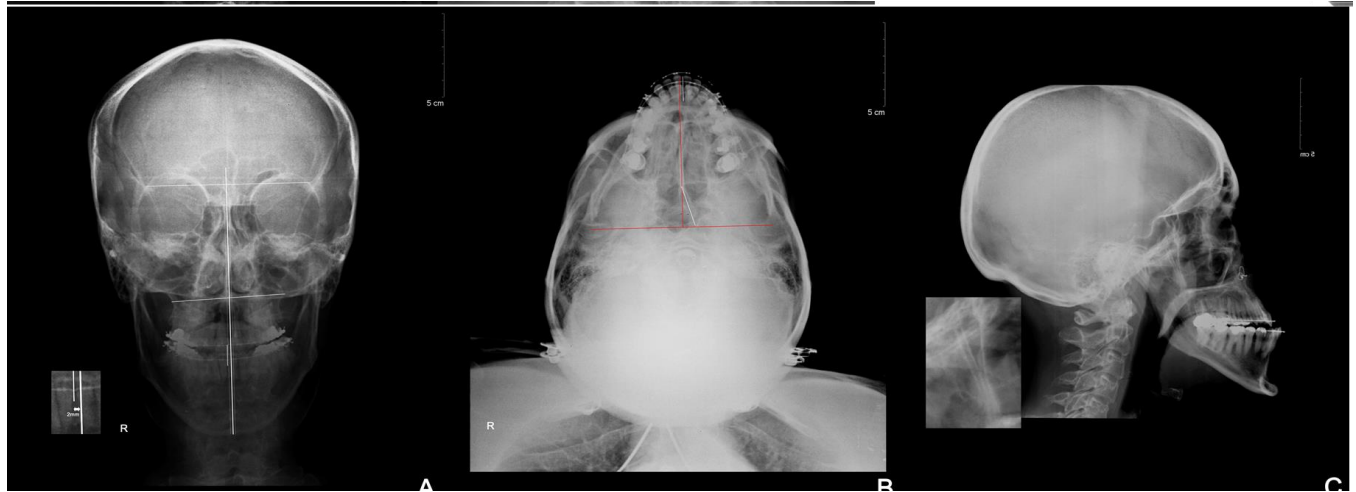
Radiographs of Subject 10 demonstrating posterior facial asymmetry and a Class III malocclusion.
